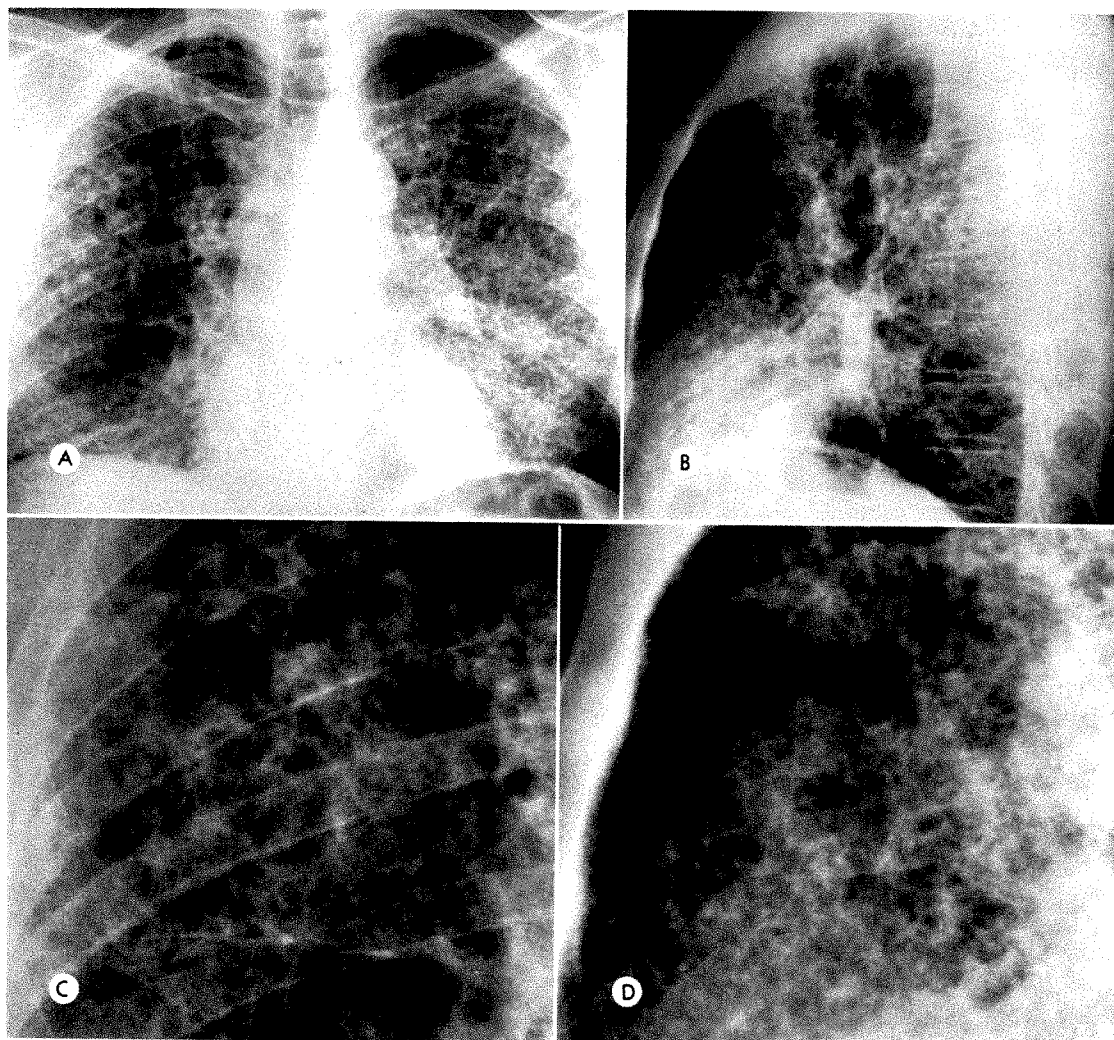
Case ix. Male, aged 48. (*A-D*) 4-24-63: (*A*) Posteroanterior roentgenogram. Marked lace-like fibrosis with multiple microcysts. (*B*) Lateral roentgenogram. (*C*) Detail of right mid-lung field in *A*. (*D*) Detail of retrosternal space in *B*.
